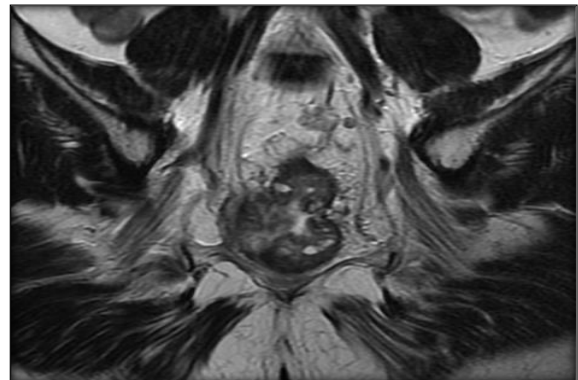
Sagittal T2W MRI shows circumferential mid-lower rectal tumor
